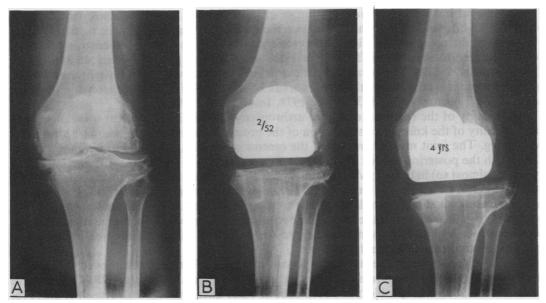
Roentgenograms of a 59-year-old woman with osteoarthrosis whose left knee was replaced in 1977. A, preoperative; the patient has had a previous high tibial osteotomy. B, two weeks postoperative. C, four years postoperative; except for a possible increase in density around the tibial implant, there is no change in the radiographic appearance
